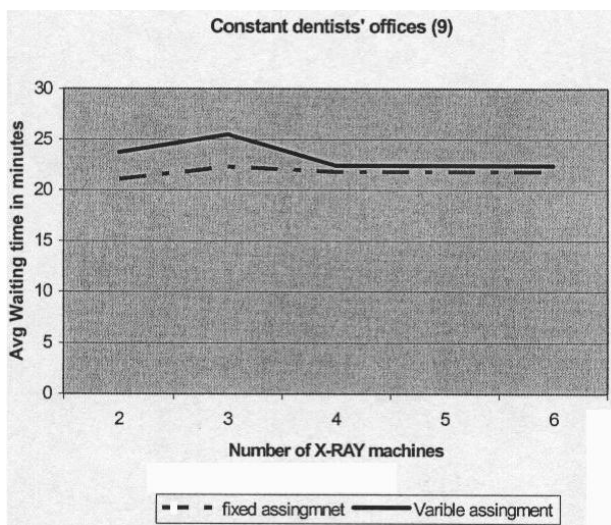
Effect of increasing the number of X-ray machines on ER patient average waiting time.
